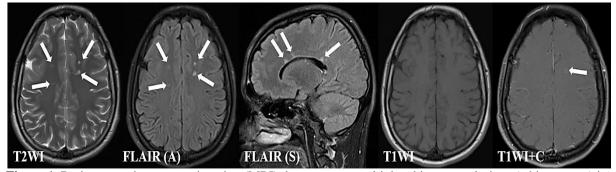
Brain magnetic resoance imaging (MRI) demonstrates multiple white matter lesions (white arrows) in the juxtacortical and periventricular regions at the level of the centrum semiovale, extending perpendicularly to the corpus callosum, as seen on T2-weighted (T2WI) and fluid attenuated inversion recovery (FLAIR) sequences – findings that may be consistent with radiologically isolated syndrome (RIS)/multiple sclerosis (MS). On post-contrast T1-weighted imaging (T1WI + C), a demyelinating plaque measuring 5 mm in diameter with mild contrast enhancement is observed in the left centrum semiovale (white arrow).
